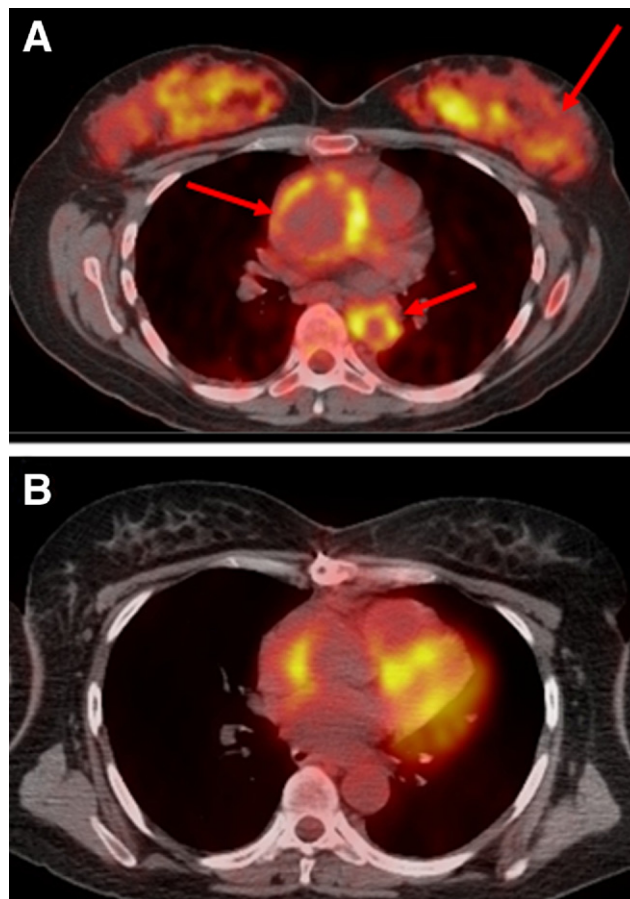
Axial FDG-PET/CT images at the level of the aortic root in a patient with Takayasu's arteritis. (A) A postpartum disease flare demonstrates transmurial uptake at the aortic root and descending thoracic aorta. Bilateral breast activity is seen secondary to breastfeeding. (B) After methotrexate therapy and cessation of lactation, both abnormalities recede.
